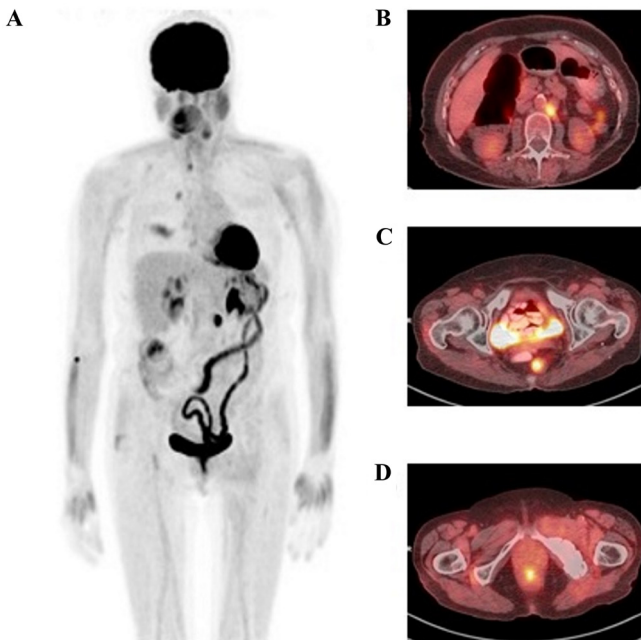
$^{18}\text{F}$ -FDG-PET/CT and efficacy of treatment (July 2018). (A) PET scan depicting metastasis in paraaortic lymph node with no evidence of any other lesions with pathologic FDG-uptake. Moderate FDG uptake was observed in the right lung due to inflammation. Co-registered PET/CT scan depicting (B) increased FDG uptake in paraaortic lymph node, and no evidence of FDG uptake in (C) node on the vagina stump and (D) left ischium. F-FDG, 2-deoxy-2-[fluorine-18]fluoro-D-glucose; PET, positron emission tomography; CT, computed tomography.
